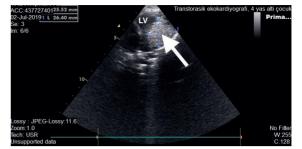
Transthoracic echocardiography apical 4-chamber view showing cardiac rhabdomyoma (arrow) in the left ventricle (LV). LA: left atrium.
